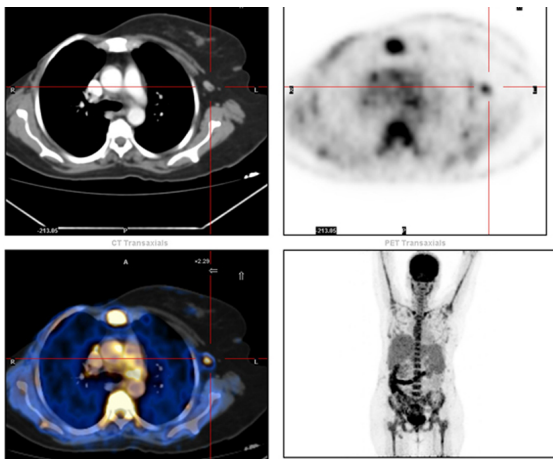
Whole body FDG PETCT transaxial images showing ¹⁸F-FDG avid left axillary lymph nodes with an SUV (standard uptake value in gm/ml) of 3.0.
